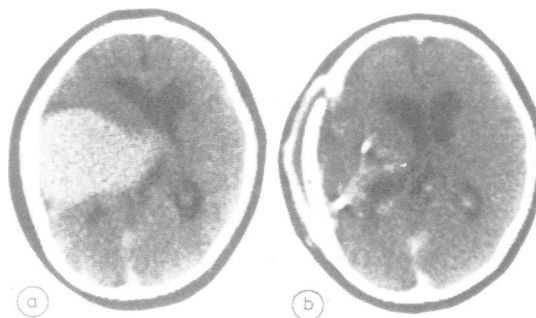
Postcontrast enhanced CT scans show a well circumscribed, enhancing giant aneurysm in left sylvian area (A) and restoration of the lateral ventricle to normal position following operation (B).
